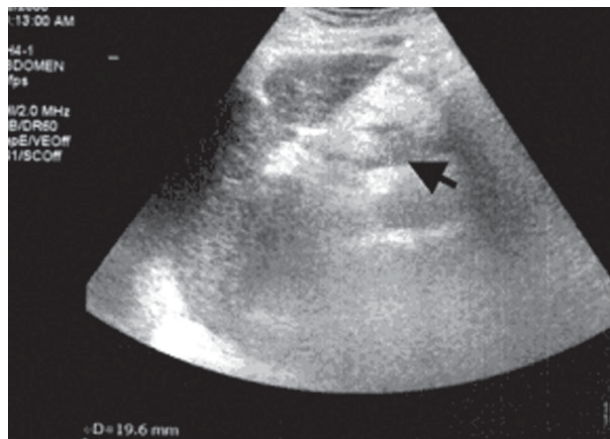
Ultrasound scan showing the residual pancreatic pseudocyst (arrow), 19 mm in diameter (a day after drainage).
